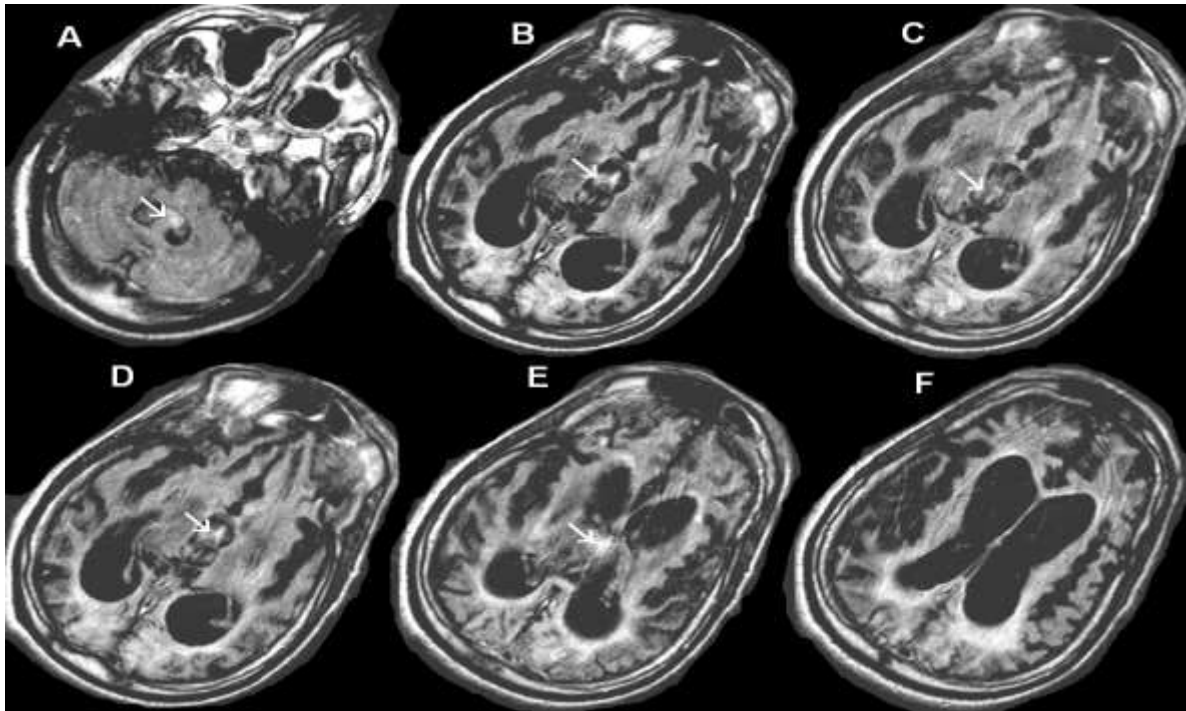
presents MRI data sets on axial views from patient OC (A to F images). MRI FLAIR axial images showed the VCSFA in the fourth and third ventricles; meanwhile, this artifact was comparatively less pronounced in the lateral ventricles, visualized as small white spots. There was also parenchymal atrophy and white matter hyperintensity. MR T1 axial images of the same patient (D to F) revealed severe brain atrophy in both cerebral hemispheres, associated with dilated ventricles and wide cerebral sulci, but no intraventricular abnormalities were found. The VCSFA was found on axial images in one patient but was not detected on sagittal planes.
